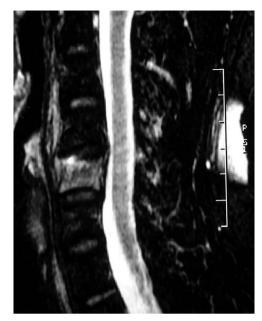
Sagittal magnetic resonance imaging of the cervical spine, T2W2, shows wedge-shaped deformity of C5 with high signal intensity.
